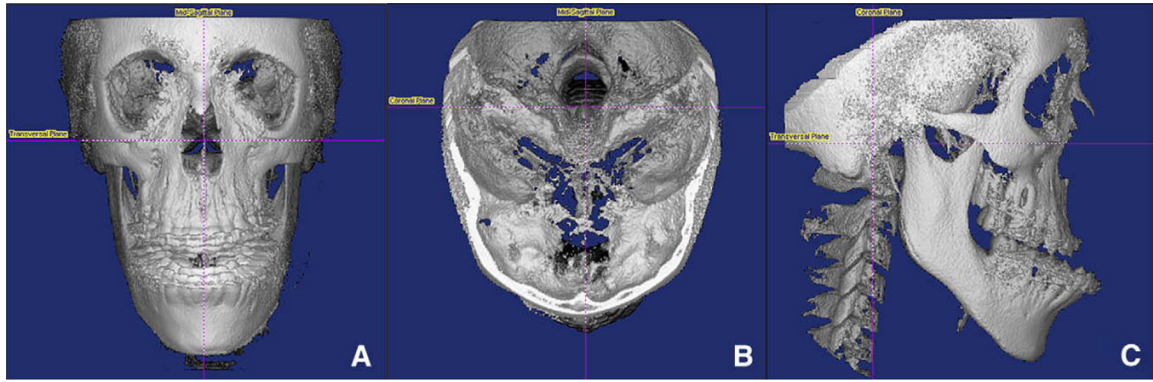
Orientation of the CBCT volume before generation of the MPR radiographic views: A, vertical orientation of the midsagittal plane; B, rotation of the transporionic axis to establish the coronal plane; C, rotation of the Frankfort plane to the horizontal orientation.
